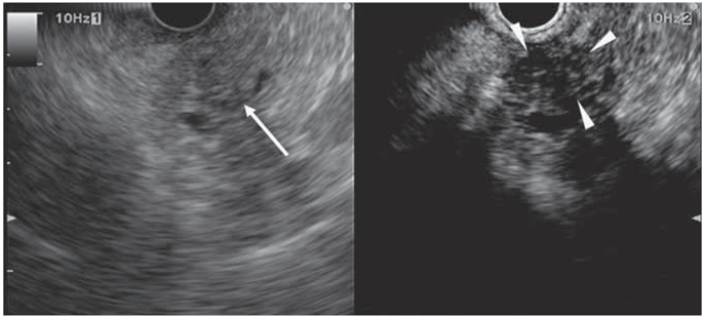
A typical example of a solid lesion with hypoenhancement (in this case, a ductal carcinoma of 15 mm in maximum diameter; see Supplementary Video S1 online). Conventional endoscopic ultrasonography (EUS; left) shows a heterogeneous area (arrow) without a clear margin at the pancreas head. Contrast-enhanced harmonic endoscopic ultrasonography (CH-EUS; right) indicates that the area is hypovascular (arrowheads) compared with the surrounding tissue.
